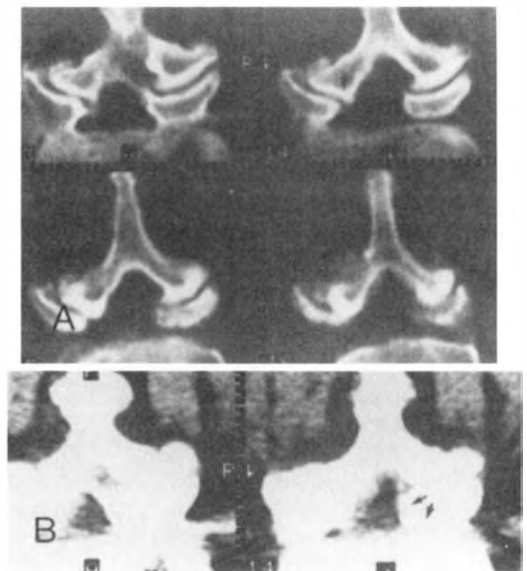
through 14.37 are studies of a 52-year-old woman who developed low back pain and ulcerative colitis in 1982. She required a colon resection in 1983. The progressive nature of her degenerative spondylolisthesis is unusually revealed by progressive x-ray studies. Figure 14.33 is a neutral lateral radiograph taken in 1982, which does not show disc degeneration or spondylolisthesis at L4. Figure 14.34, taken in 1984, does show disc degeneration of the L4–L5 disc, with anterior subluxation of L4 on L5 by about 8 mm. Figure 14.35, made in 1987, shows advanced degenerative changes of the L4–L5 disc, with total loss of disc space and permanent stabilization of L4 on L5. Figures 14.36 and 14.37 are the axial and sagittal reformation showing the extensive L4–L5 discal degeneration and the L4 pseudospondylolisthesis. Note the rotatory subluxation of the inferior facets with narrowing of the lateral recesses and sagittal diameter of the vertebral canal.
